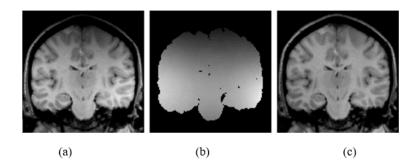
(a) MRI image of the brain before inhomogeneity field or bias field correction, (b) inhomogeneity field or bias field, and (c) MRI image of the brain after bias field correction. [41].
